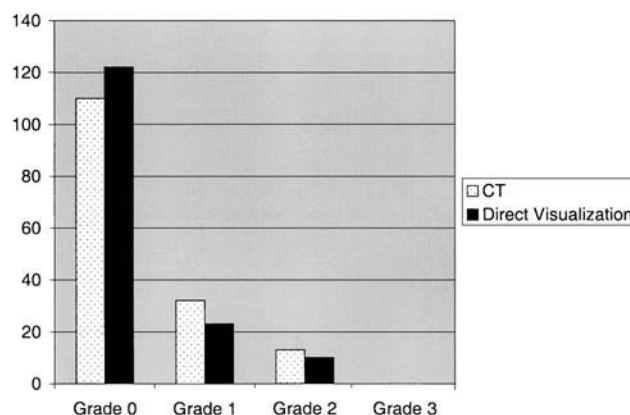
Graph demonstrating grades obtained for CT scanning and direct visual inspection.
